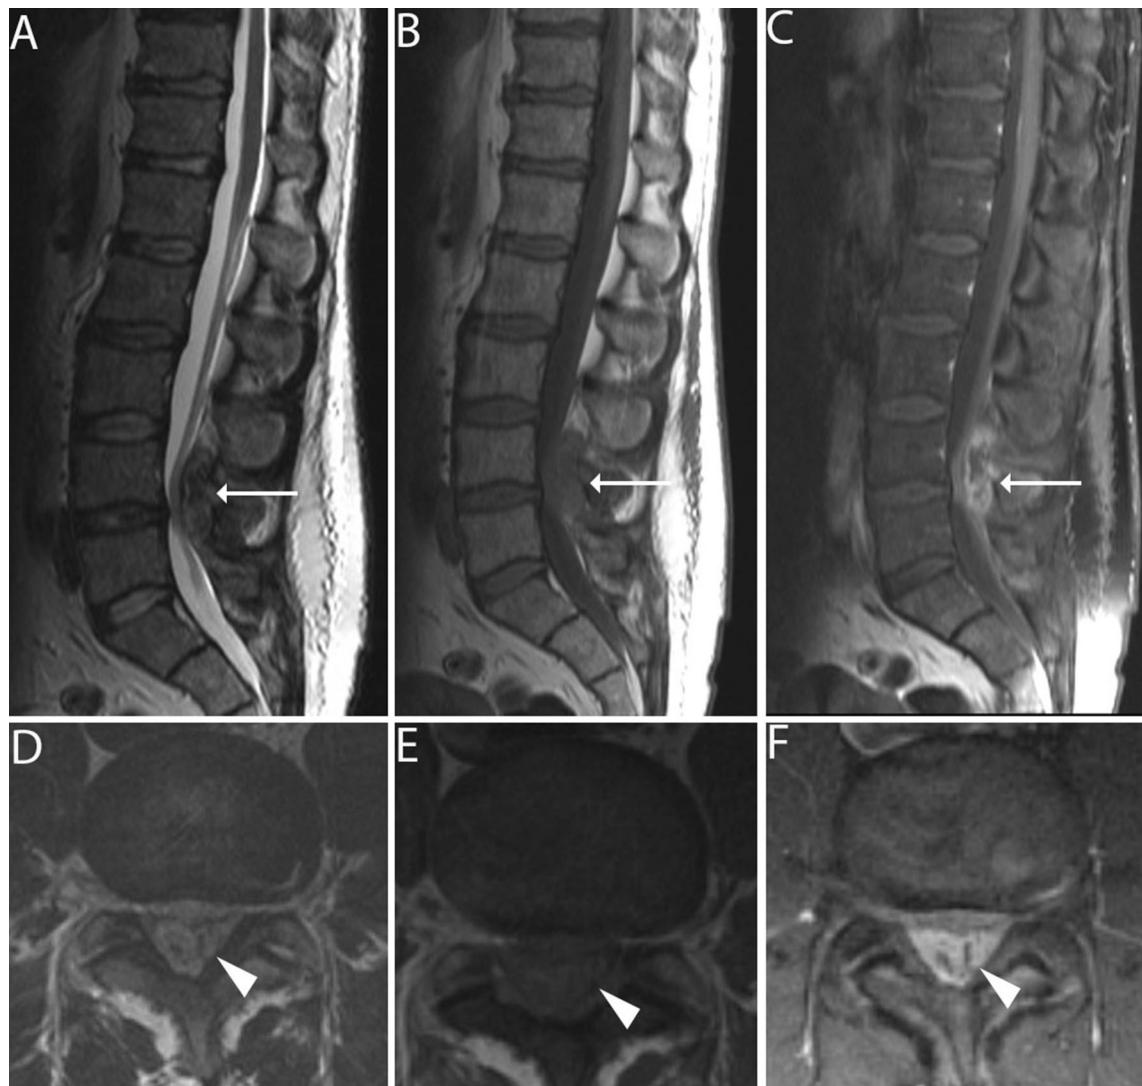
a, d Sagittal and axial T2 weighted MRI demonstrating L4/5 epidural lesion with thecal sac compression; b, e sagittal and axial T1 pre-gadolinium MRI demonstrating L4/5 epidural lesion; c, f sagittal
